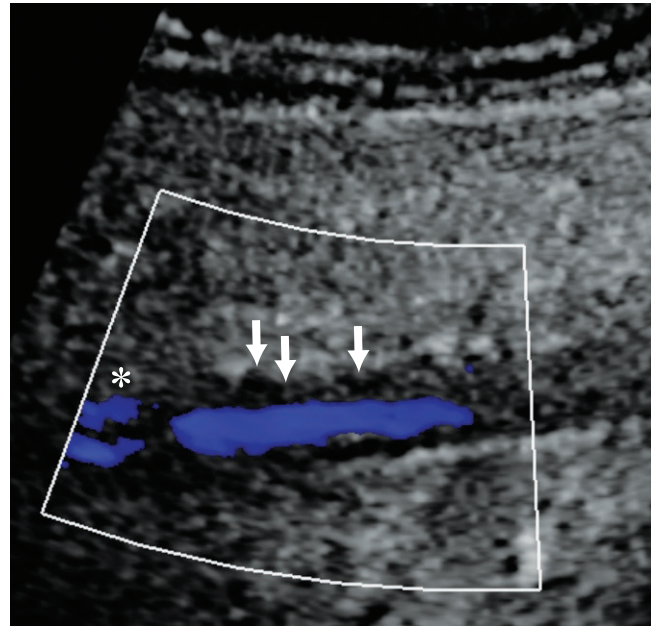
In a different patient long axis color Doppler of a popliteal vein with residual venous thrombosis demonstrates the scarring as irregular thickened vein wall (arrows). The majority of the color lumen is central representing recanalization. More proximally, the scarring has left two channels of flow (*).
